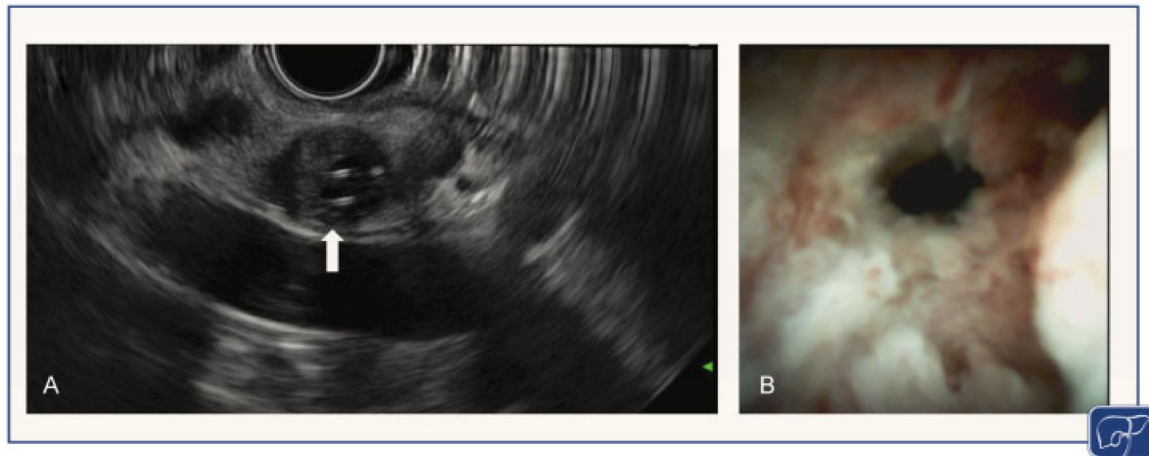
Advanced endoscopic techniques for the diagnosis of perihilar cholangiocarcinoma (pCCA). (A) Digital cholangioscopy demonstrating an infiltrative stricture with dilated vessels in a patient without a mass seen on cross-sectional imaging. Cholangioscopy-targeted biopsies confirmed the presence of adenocarcinoma. (B) Endoscopic ultrasound (EUS) image demonstrating a 1-cm mass (white arrow in A) of the common hepatic duct, corresponding with a perihilar cholangiocarcinoma with a plastic stent traversing within the bile duct.
